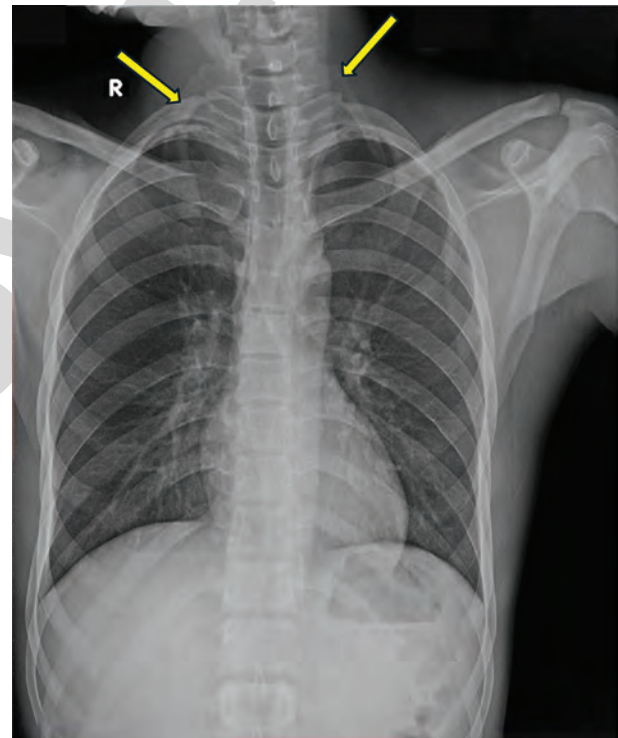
Radiograph of case of leukemia showing bilateral cervical rib (yellow arrow)
